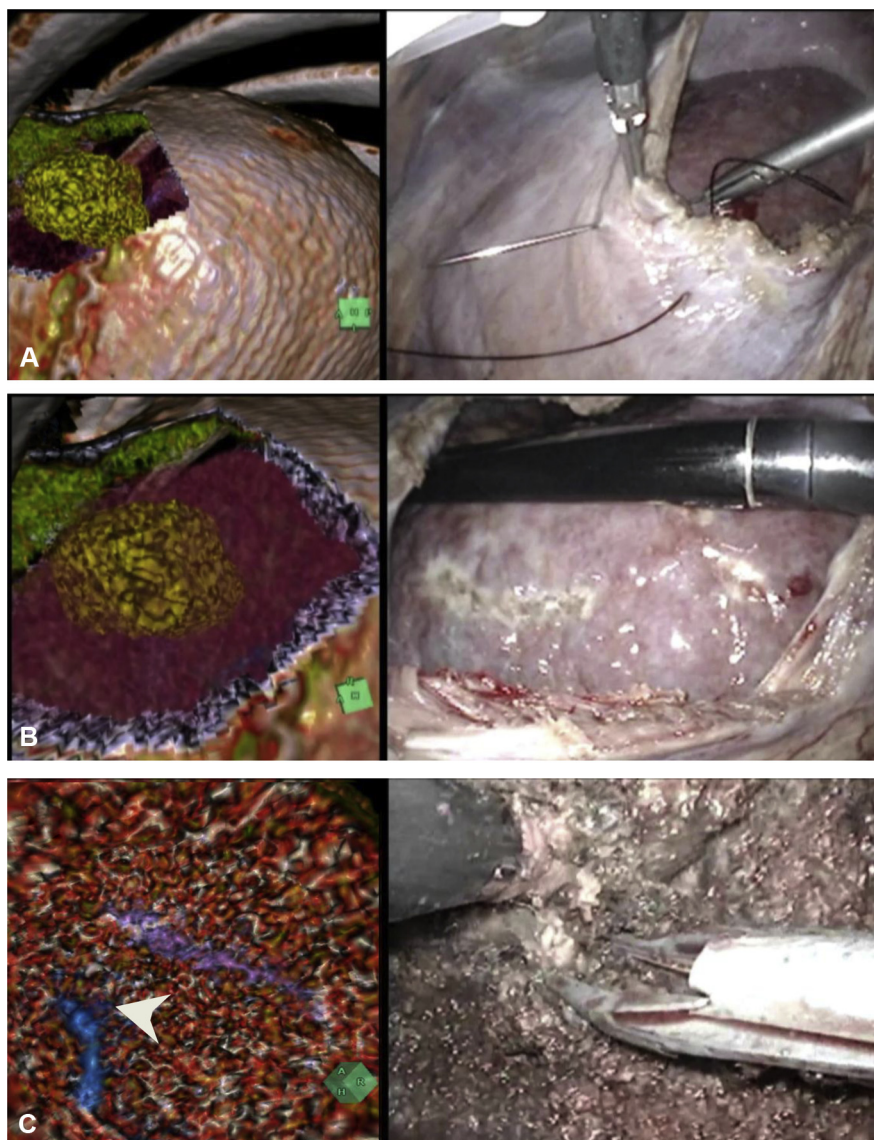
Each row shows the 3-dimensional virtual endoscopy (3DVE) image (left column) and the original laparoscopic camera image (right column). (A) The tumor location was confirmed on the 3DVE, and then the portion of the diaphragm located just above the tumor was opened. (B) Intraoperative thoracoscopic ultrasonography was performed on the liver surface to identify the tumor margin. (C) Clips were applied on segmental branch 8 of the portal vein before dissection (arrow). See [Supplementary Video 1](#).
